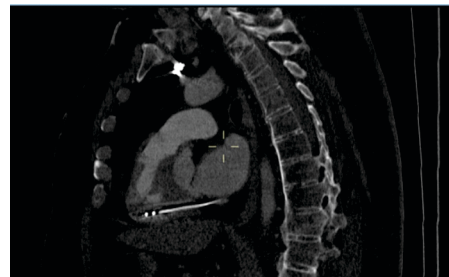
CT CAP showing T2 lesion but no primary malignancy
